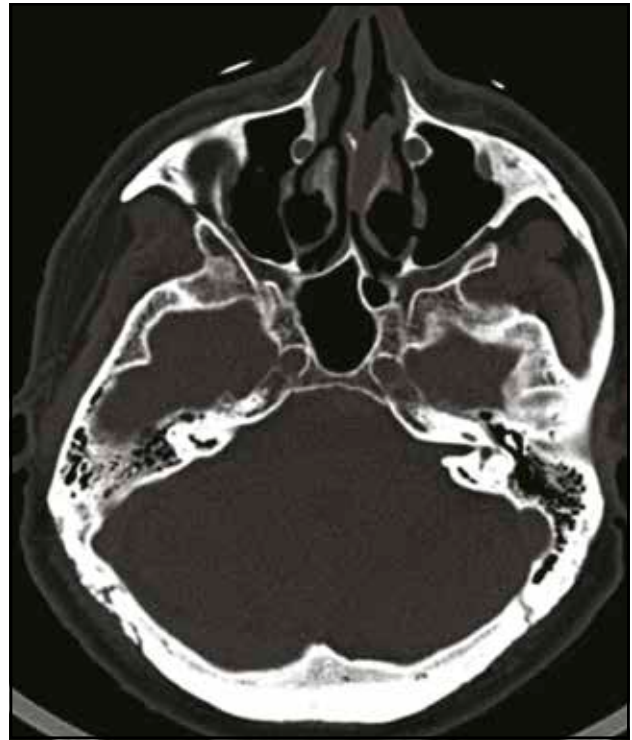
Cranio-facial CT scan, axial section, performed in 2020 – insertion of the nasal tumor, detected at onset, at the level of the external portion of the left middle turbinate, without involvement of adjacent structures.
